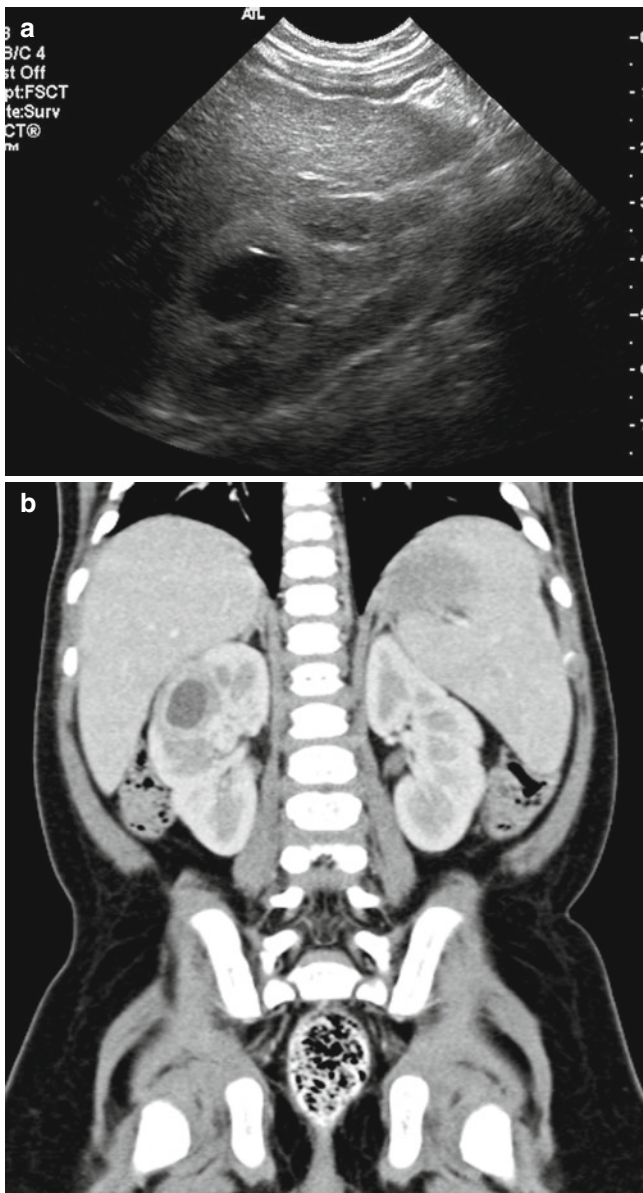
Renal abscess.* Sagittal US of the right kidney (a) shows round hypoechoic abscess surrounded by hyperechoic, inflammatory parenchyma. Corresponding contrast-enhanced CT (b) demonstrates the abscess formation with wall enhancement
